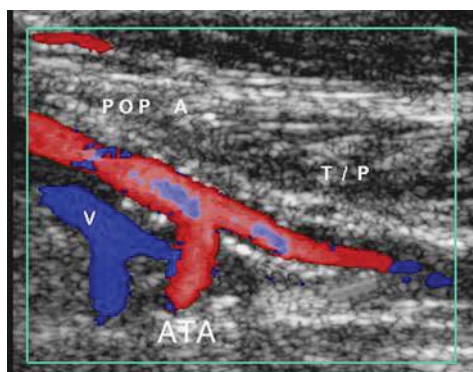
At this point the anterior tibial artery should be seen coursing posteriorly. A Doppler reading may be taken at this point.
